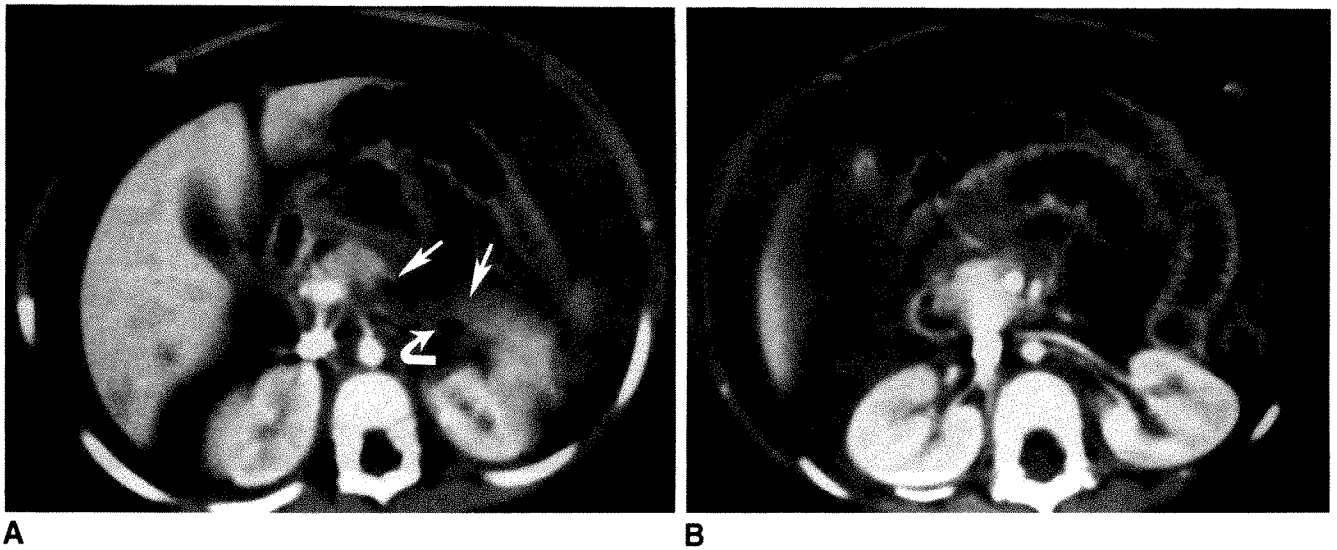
2-year-old abused girl. Her blood pressure was unobtainable on arrival at emergency room. She responded to resuscitative measures and appeared to be clinically stable at the time of CT. She had a severe metabolic acidosis (pH, 6.84; base deficit, -28).
